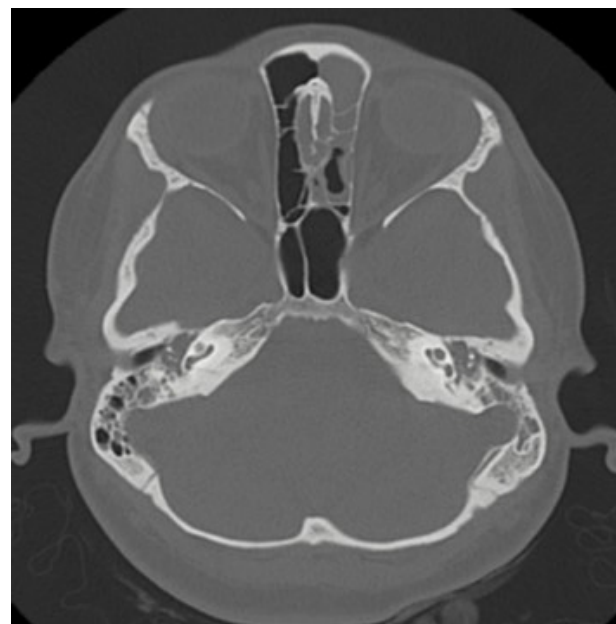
Axial temporal bone CT scan showing middle ear and mastoid effusion.
